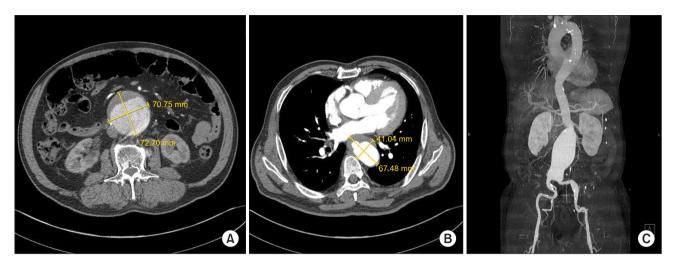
Preoperative computed tomography angiography (CTA) showing 6.7×4.1 cm descending thoracic aneurysm (A) and 7.0×7.2 cm abdominal aortic aneurysm (B), and three-dimensional reconstruction CTA shows both aneurysms (C).
